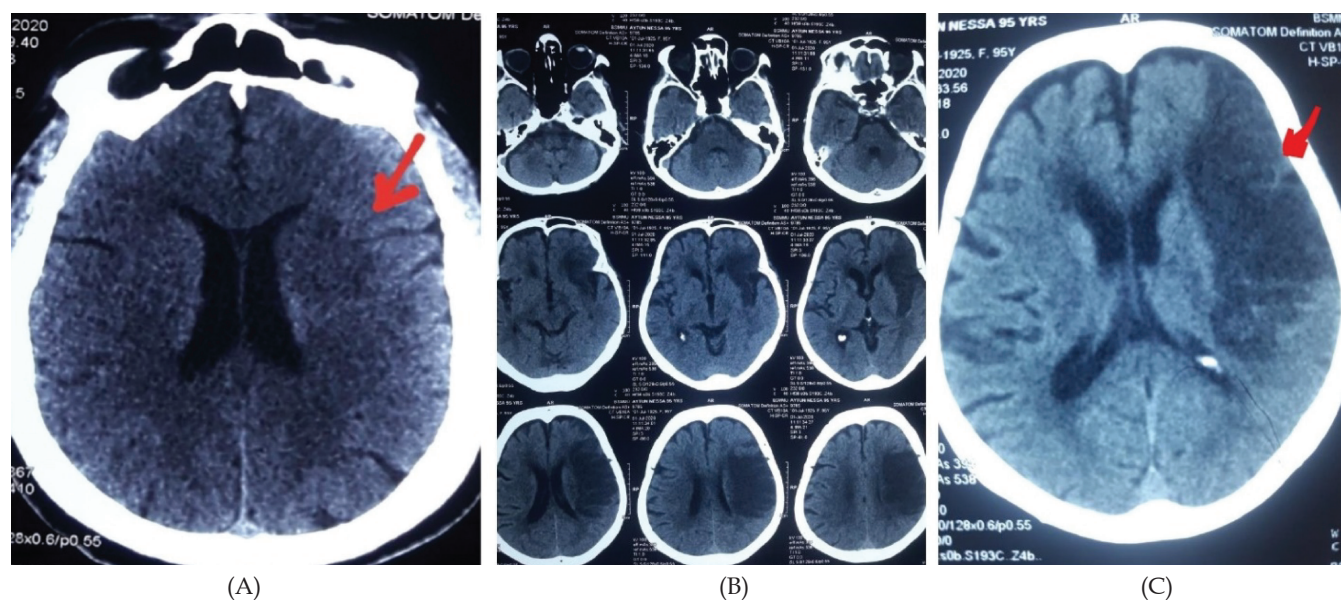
(A, B, C) CT scan of brain demonstrating acute left Middle Cerebral Artery stroke (Shown as arrow)
